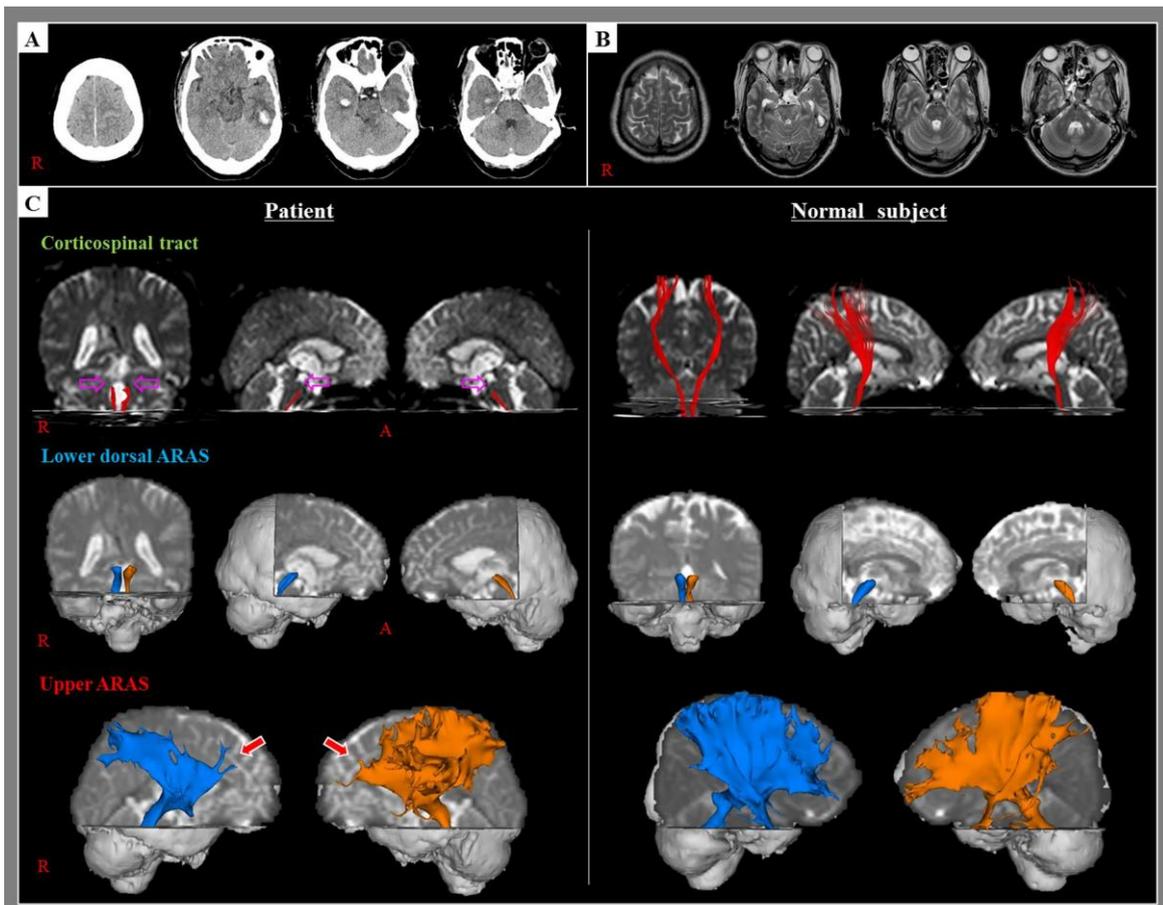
(A) Brain computed tomography images taken at onset show multiple cerebral contusional hemorrhages. (B) Brain magnetic resonance images taken at 5 weeks after onset show multiple small leukomalactic lesions in the subcortical white matter including that in the left frontal area and the right thalamus. (C) Results of diffusion tensor tractography (DTT) for the corticospinal tract (CST) and ascending reticular activating system (ARAS). The CST is discontinued at the midbrain level (pink arrows) in both hemispheres compared to that in a normal subject (51-year-old female). However, the lower dorsal and upper ARAS showed intact configurations except for decreased neural connectivity to the prefrontal lobe of the upper ARAS (red arrows) in both hemispheres compared to a normal subject (48-year-old female).
